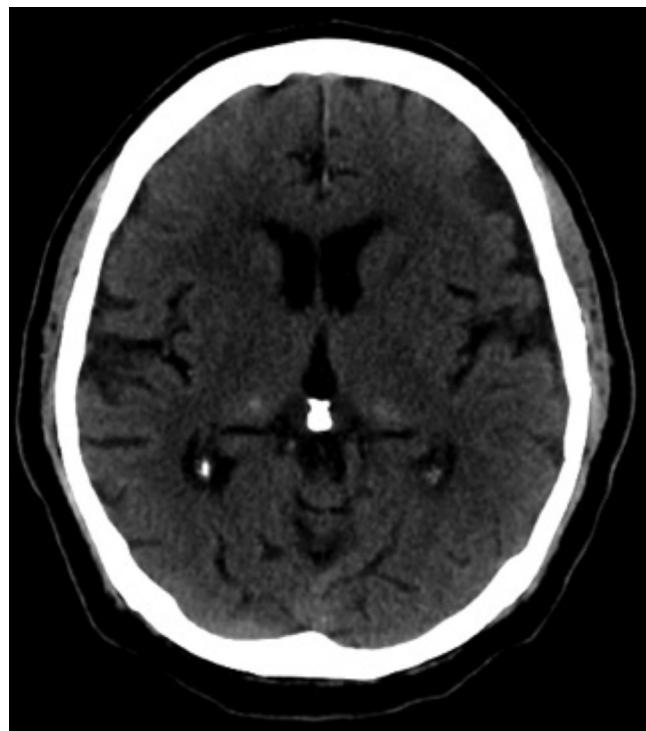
Brain CT. Hyperdensities can be seen in both pulvinar nuclei.
